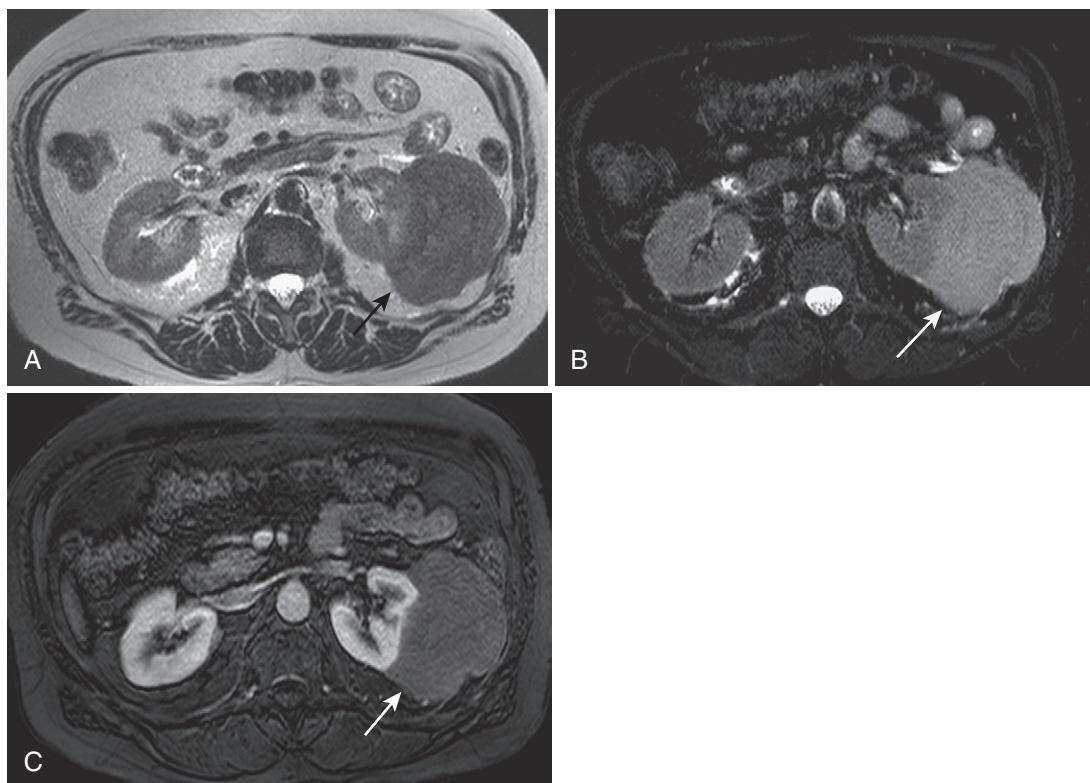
Renal lymphoma. A, The axial T2-weighted image reveals a large left-sided lesion (*arrow*) that exhibits multiple features typical of lymphoma: (1) T2 hypointensity, (2) involvement of the perinephric space, and (3) lack of necrosis despite large size. B, Note the relative hyperintensity (*arrow*) on the fat-suppressed T2-weighted image, benefiting from increased dynamic range. C, The early postcontrast image shows characteristic minimal enhancement (*arrow*).
